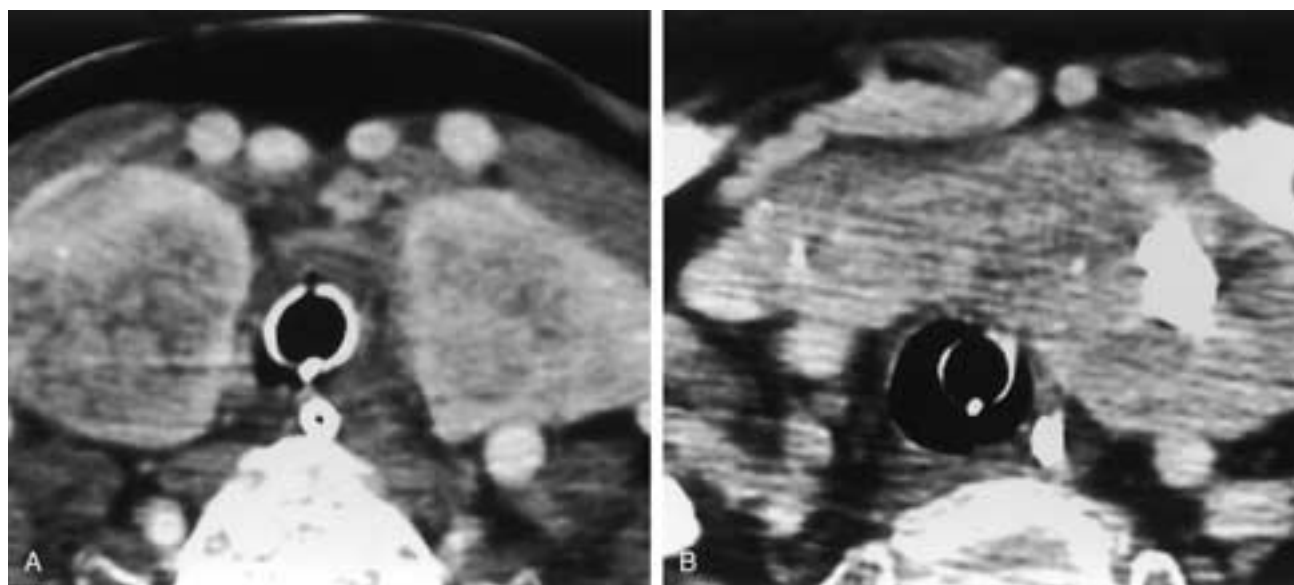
Multinodular goiter with substernal extension. A, Enhanced axial CT scan reveals extensive enlargement of the thyroid gland with diffuse heterogeneous hypodensity. The patient has an orotracheal tube in place. B, There was substernal extension of the thyroid goiter. Multiple calcifications are also noted.
